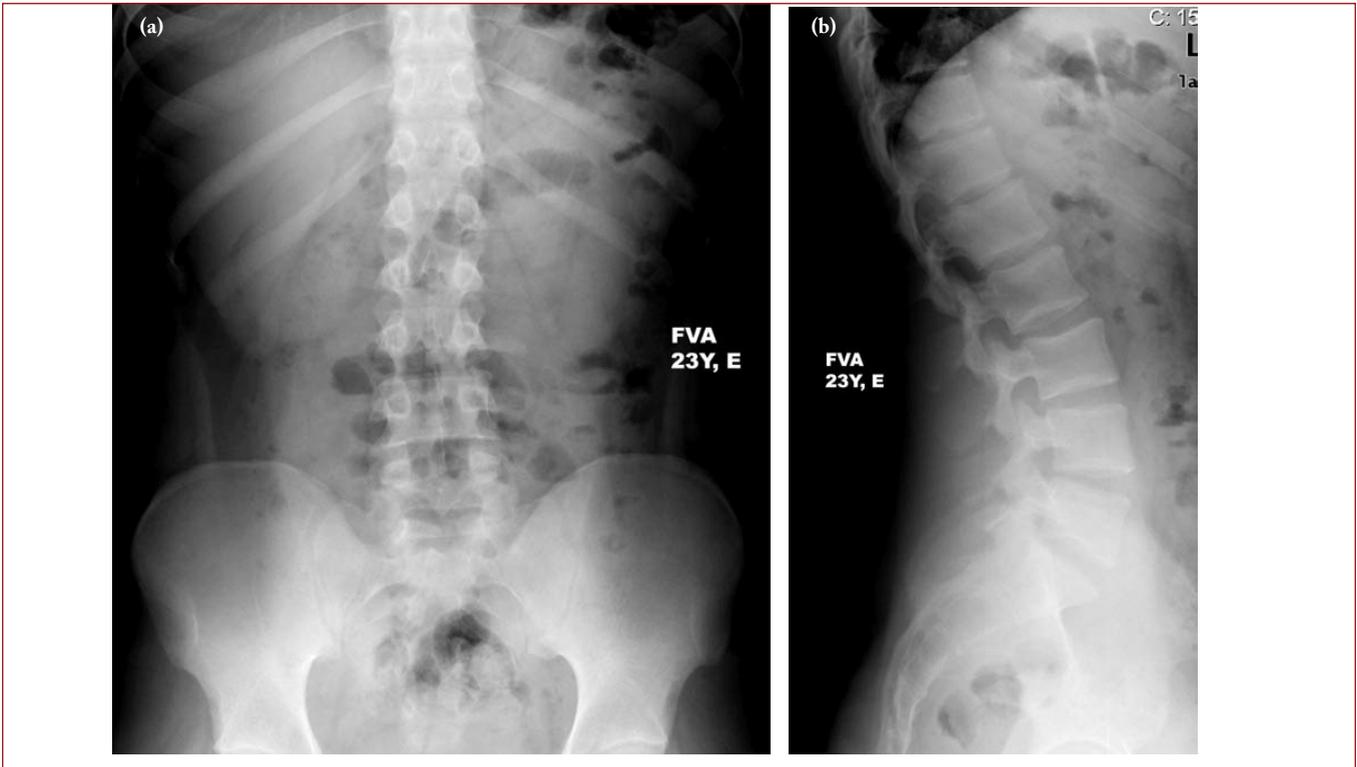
A 23-year-old male patient (F.V.A.). a. In anteroposterior lumbosacral X-rays, occult spina bifida is visible at the L5 and S1 levels, b. Lateral lumbosacral X-ray.
